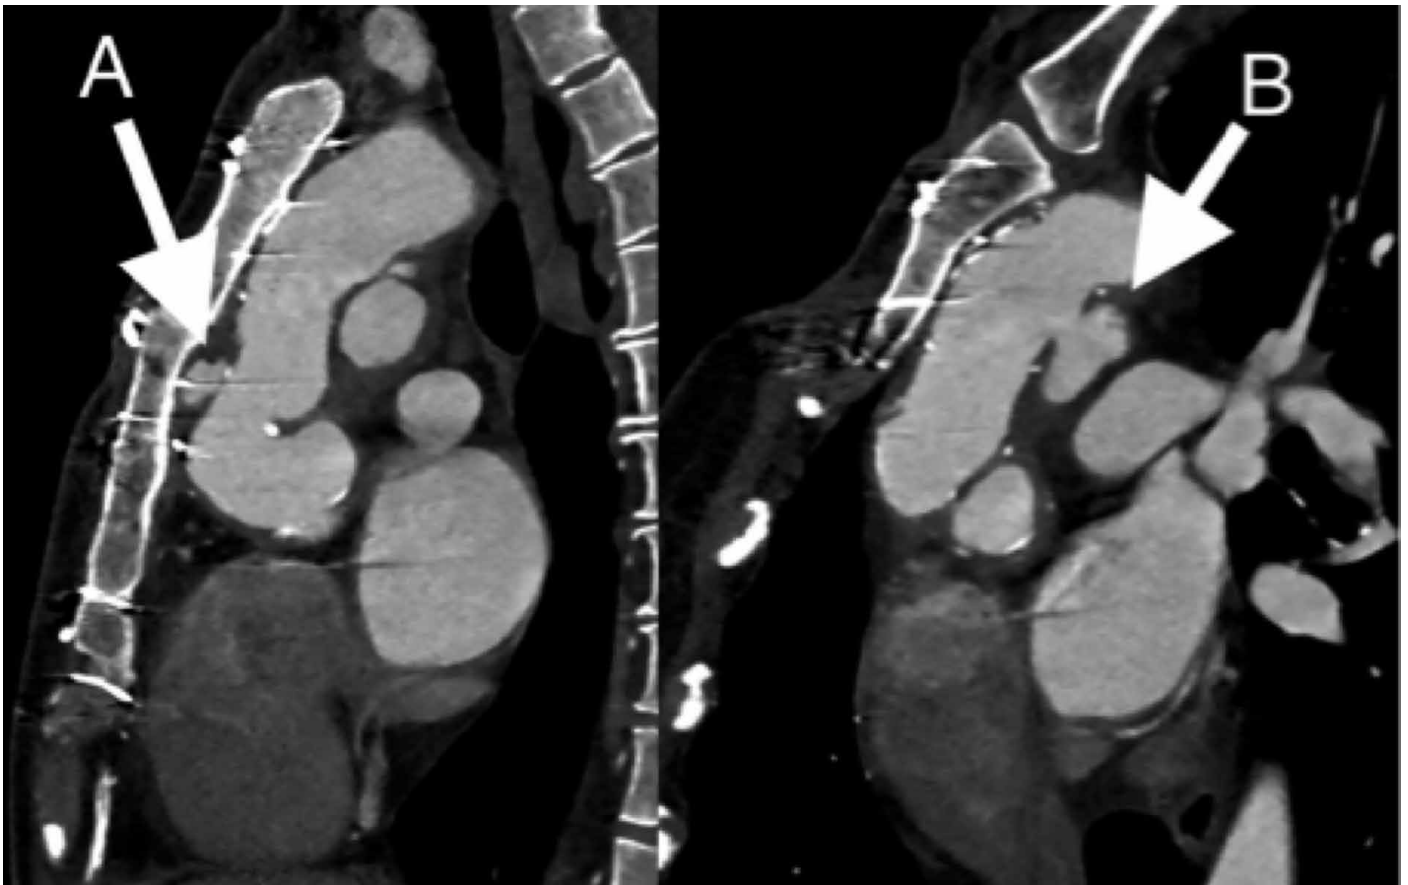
A sagittal computed tomography aortography. Figure 2a shows the proximal pseudoaneurysm (A) and its relation to the posterior side of the sternum. Note also the proximity of the homograft to the sternum. Figure 2b shows the distal pseudoaneurysm (B), along with its neck.
